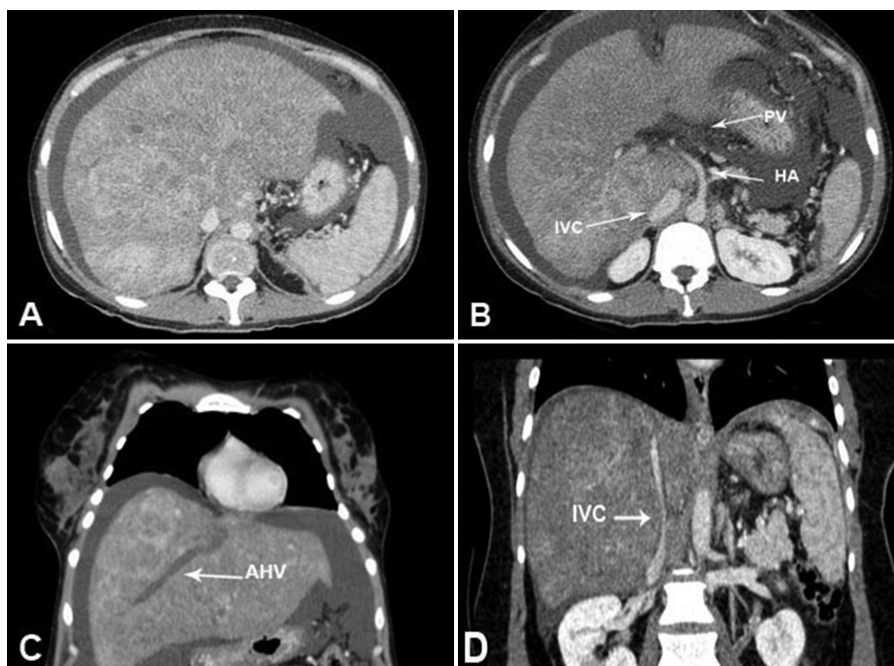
Abdominal computed tomography—portal phase. A – Attenuation coefficient heterogeneity of the hepatic parenchyma. B – Portal vein (PV) thrombosis compression of the inferior vena cava (IVC) by the caudate lobe. C – Unfilled anomalous hepatic vein. D – Narrowing of the inferior vena cava. AHV = anomalous hepatic vein. HA = hepatic artery.
